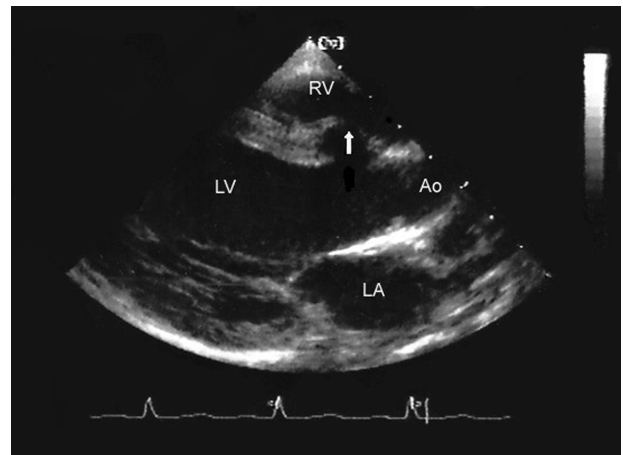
Cross sectional echocardiographic imaging in the parasternal long-axis view showing prolapse of the anterior sinus into the right ventricle outflow tract (arrow), mimicking an aneurysm of the membranous septum. LV: left ventricle; LA: left atrium; RV: right ventricle; Ao: aorta.
